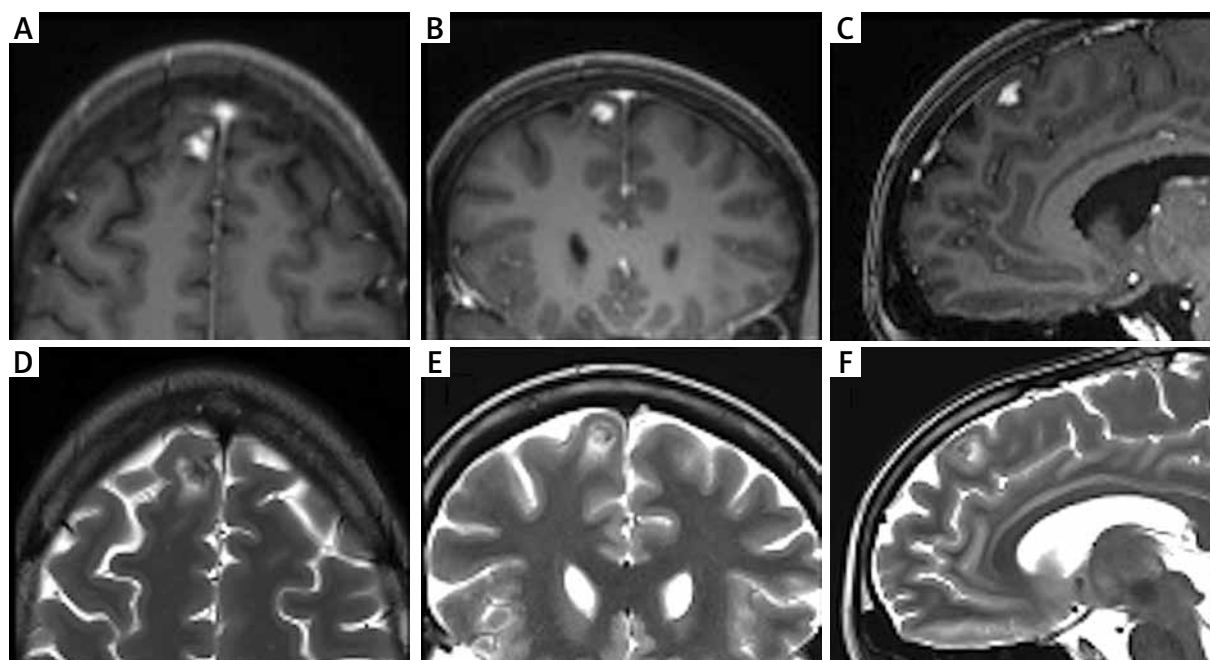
Preoperative MRI. A-C) A small irregular intraparenchymal lesion with enhancement in postcontrast T1-weighted sequences (axial, coronal and sagittal sequences, respectively). D-F) Depict the corresponding T2-weighted images.
